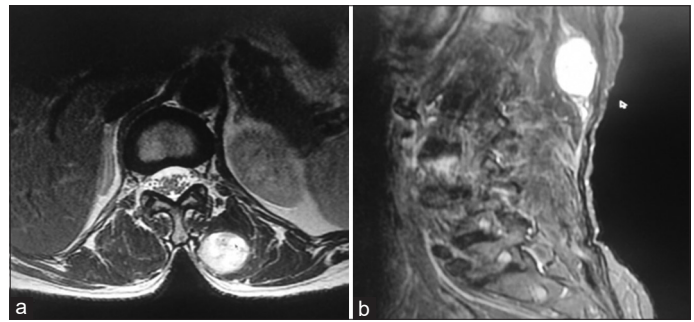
(a and b) T2w MRI images showing well-defined inhomogeneously hyperintense lesion on axial and sagittal sections
